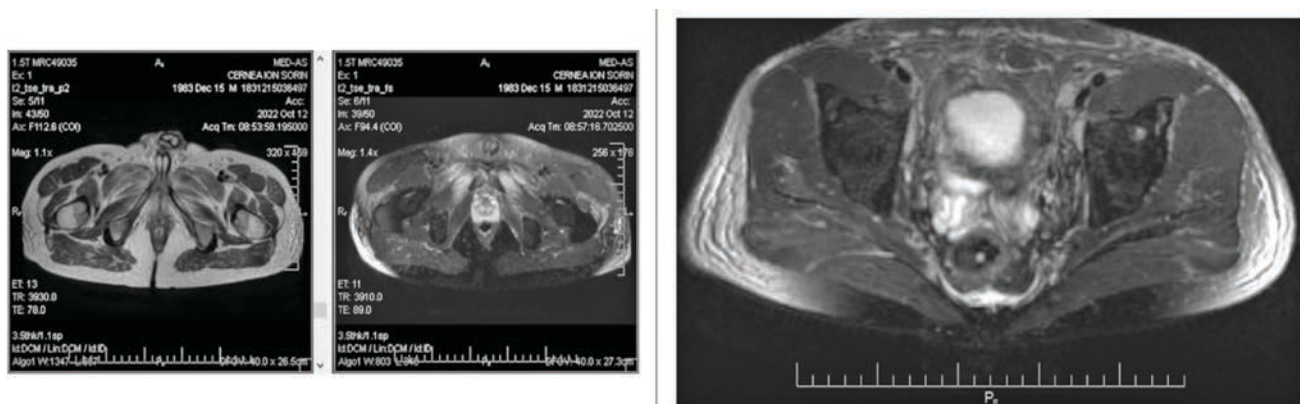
Diagnostic MRI showing oedema and fluid anteriorly of sacrum and pelvis
